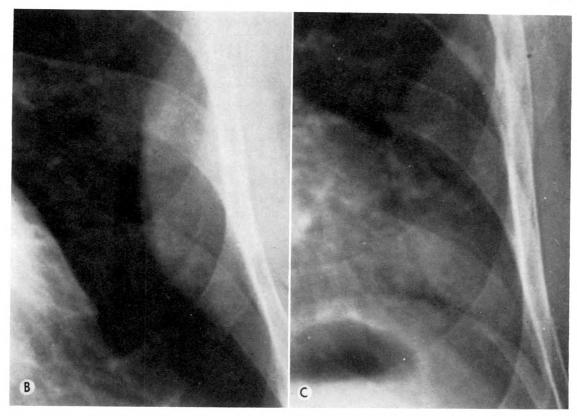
Comparison of the spot roentgenograms made at inspiration (B) and expiration (C) reveals an over-all diminution in the size of the mass during inspiration with some local flattening of the contour inferiorly. Also, a band-like density which projects over the base of the lesion disappears during expiration. This line is probably pleural in origin and related to compression of the lipoma.
